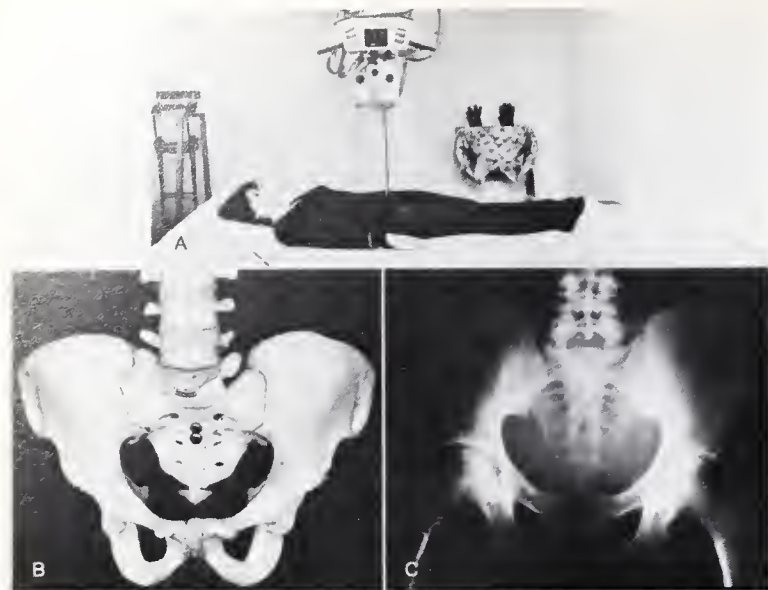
A. For the anteroposterior projection, the beam is directed perpendicular to the midpelvis and the radiological plate. B. Anatomical appearance of the pelvis in the anteroposterior plane. C. Radiographic appearance of the pelvis in the anteroposterior plane. Copyright (c) 1984 and published by Williams & Wilkins, Co. Baltimore, MD 21202. Reprinted by permission.
